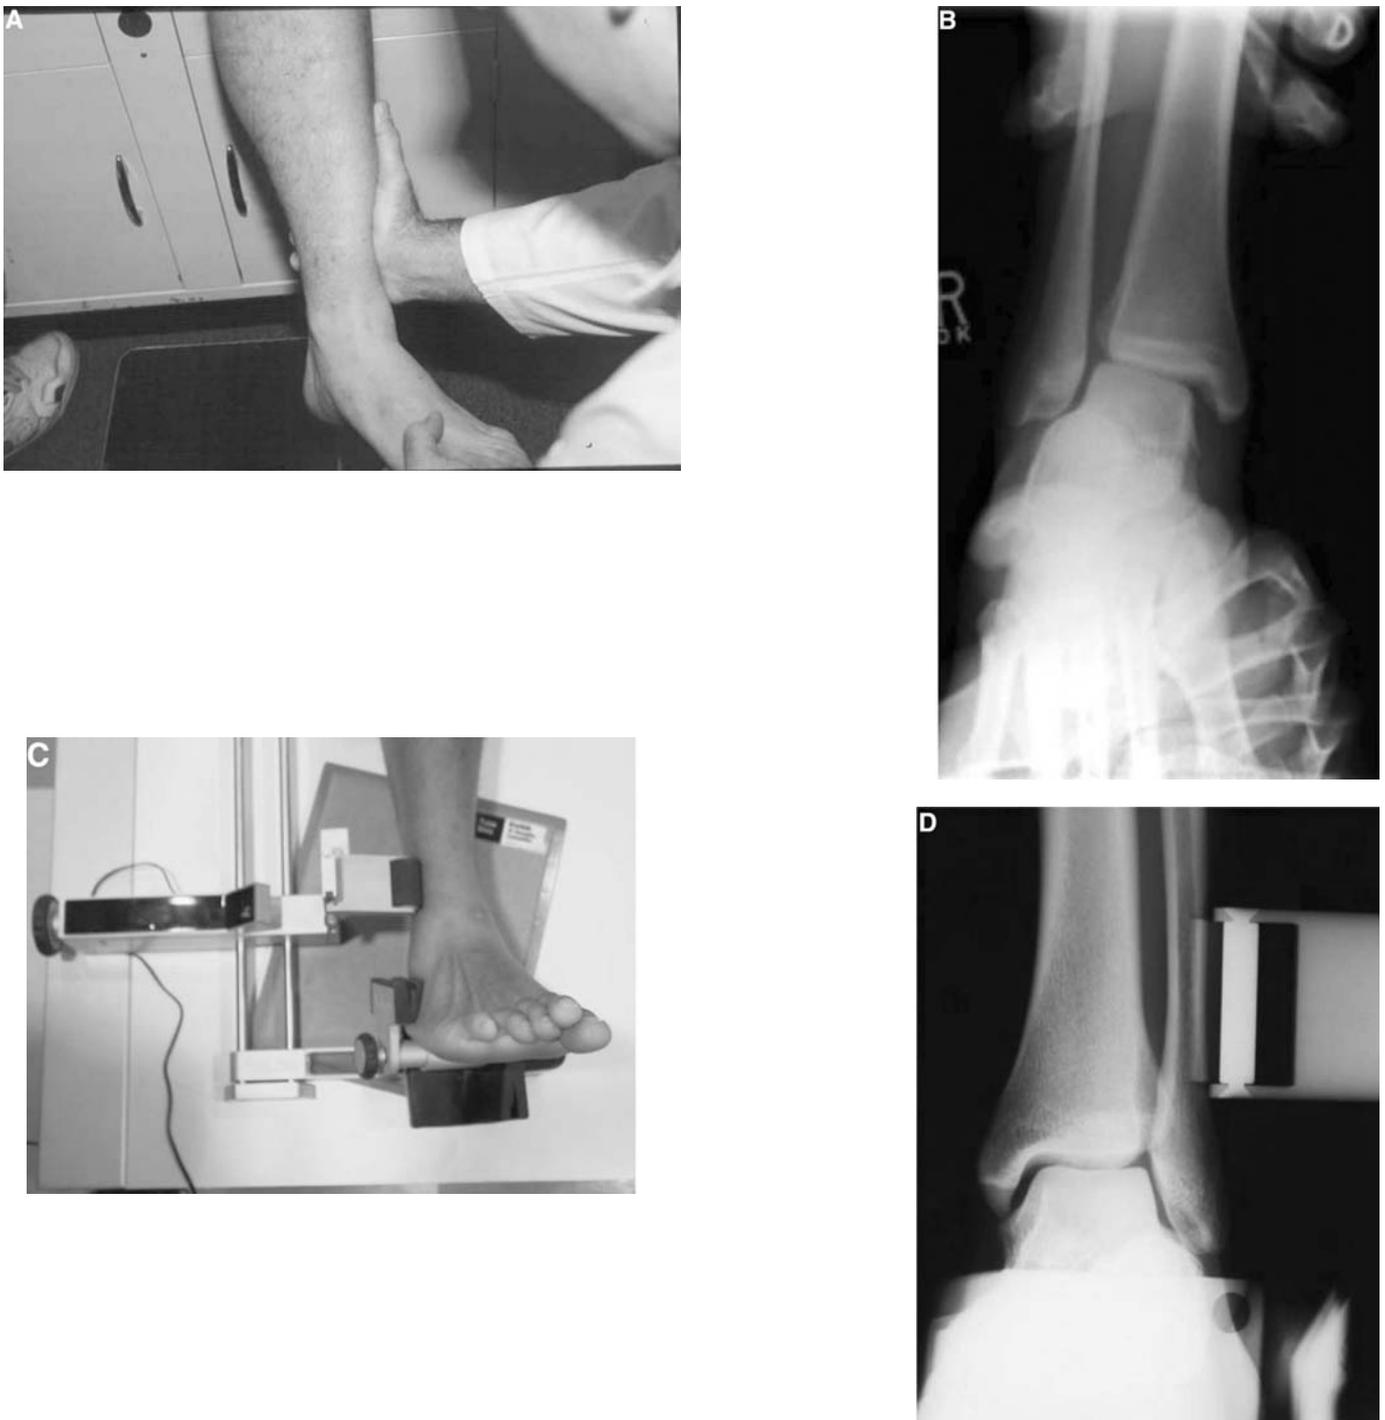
A, the manual external rotation test. B, radiographic view of a right ankle demonstrating diastasis. C, external rotation test using a standardized Telos machine. D, radiographic view of the left ankle during the external rotation test.
